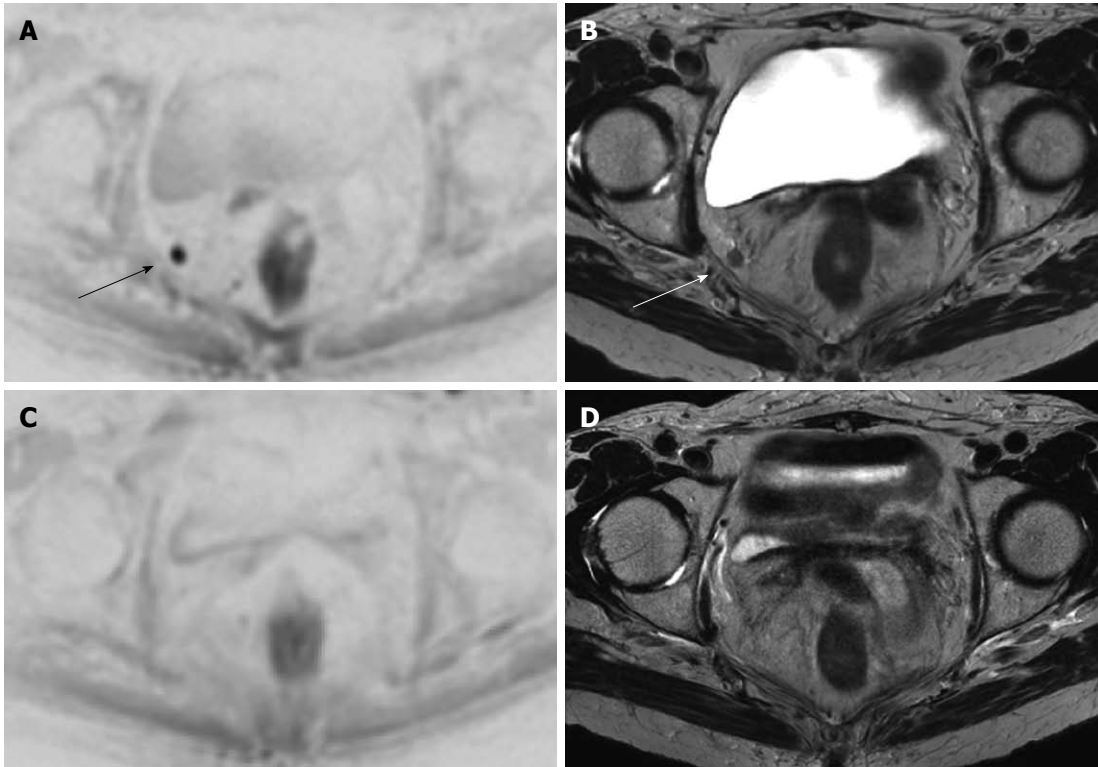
Same case as Figure 2. An enlarged right obturator lymph node is suspected in this patient with a lower third rectal cancer. Diffusion weighted imaging (DWI) (A) and axial T2w (B) images show the enlarged obturator lymph node nicely (arrows). DWI (C) and axial T2w (D) images following chemoradiotherapy show that the lymph node has disappeared
